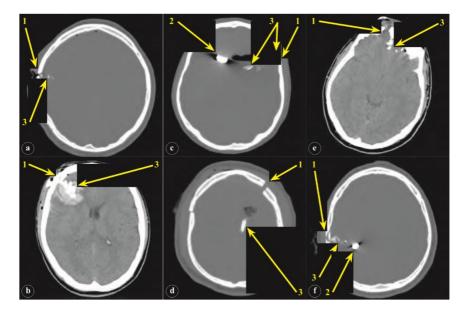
Hollow fractures of the skull. Computed tomographies of six different wounded patients.
